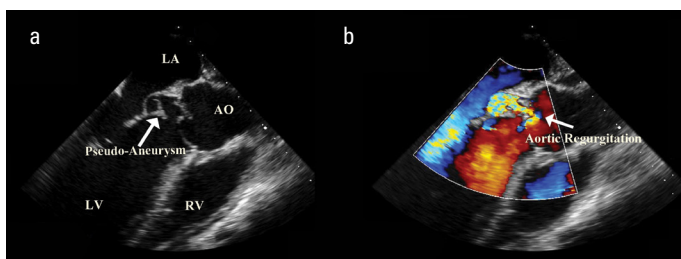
a-b. (a) Two-dimensional transesophageal echocardiography of MAIVF pseudoaneurysm. (b) Pseudoaneurysm cavity filled with aortic regurgitation
